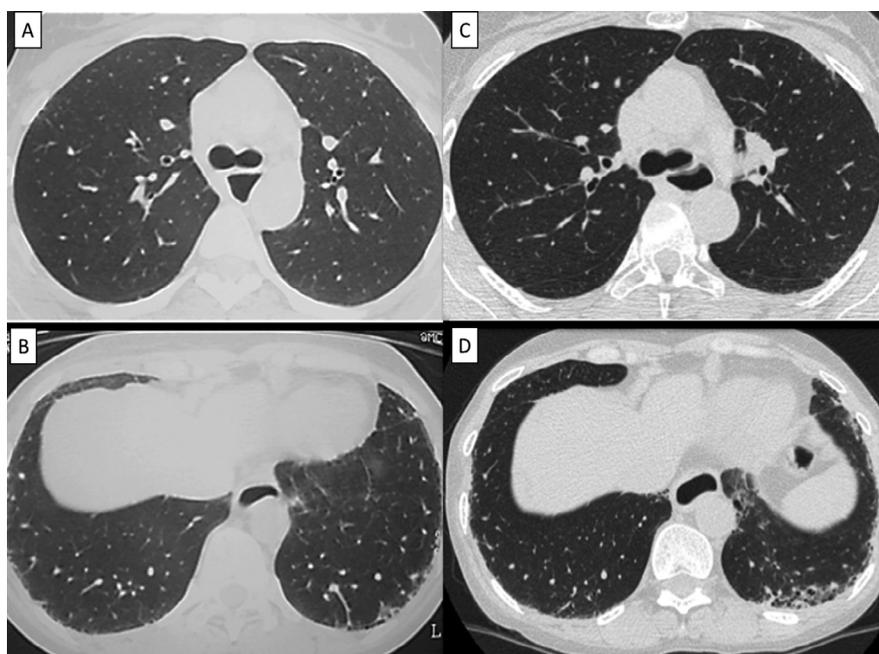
The most prevalent image findings in MCTD were ground-glass opacities and reticulation, predominantly in the periphery of the lower lobes. Slides C and D show the same patient as slides A and B, after 10 years. There is mild progression of disease with an increase in signs of fibrosis, (traction bronchiolectasis and an elevated left diaphragmatic dome). The baseline lower-lobes %ILD-HRCT score was 7.5% and the follow-up score was 12.5%.
